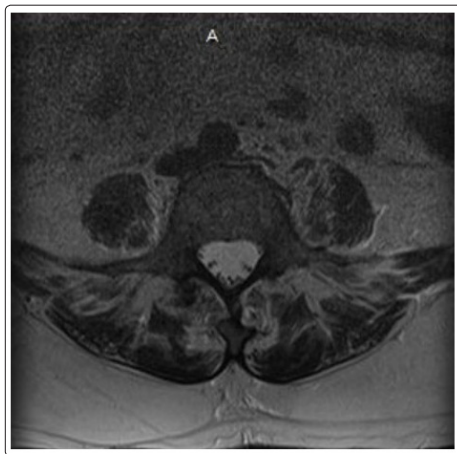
MRI Lumbar Spine demonstrating abnormal T2 bright signal within the left psoas muscle and bilateral erector spinae
